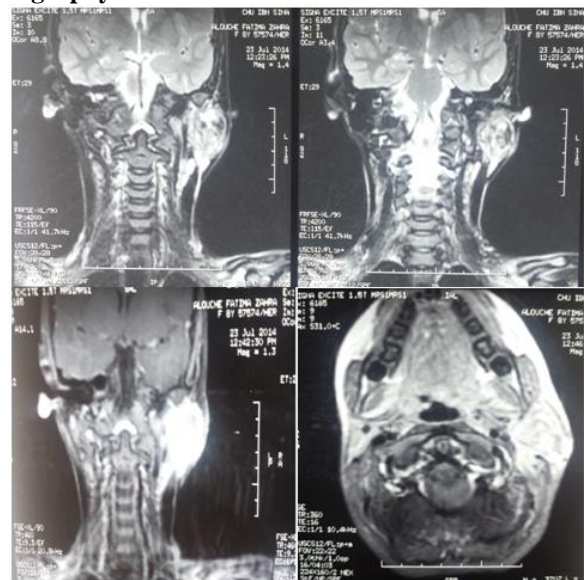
MRI in coronal and axial section shows the tumor of the left parotid.
